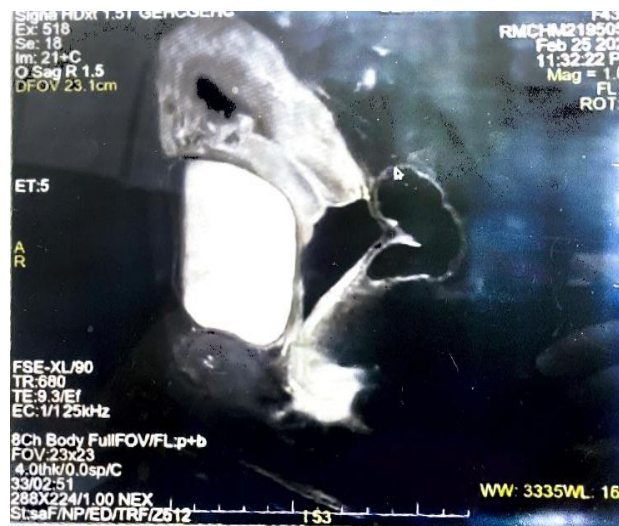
Sagittal T2-weighted pelvic MRI demonstrating retained products of conception with focal myometrial invasion consistent with placenta increta.
